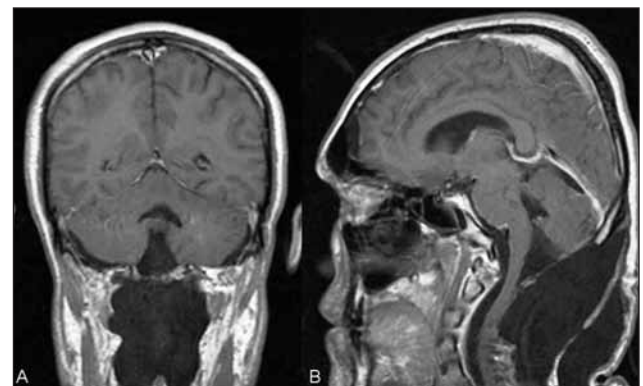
Post-operative cranial coronal (A) and sagittal (B) MRI showed total removal of the tumor. No contrast enhancement was seen at the operational area when IV contrast (gadolinium) was administered.
